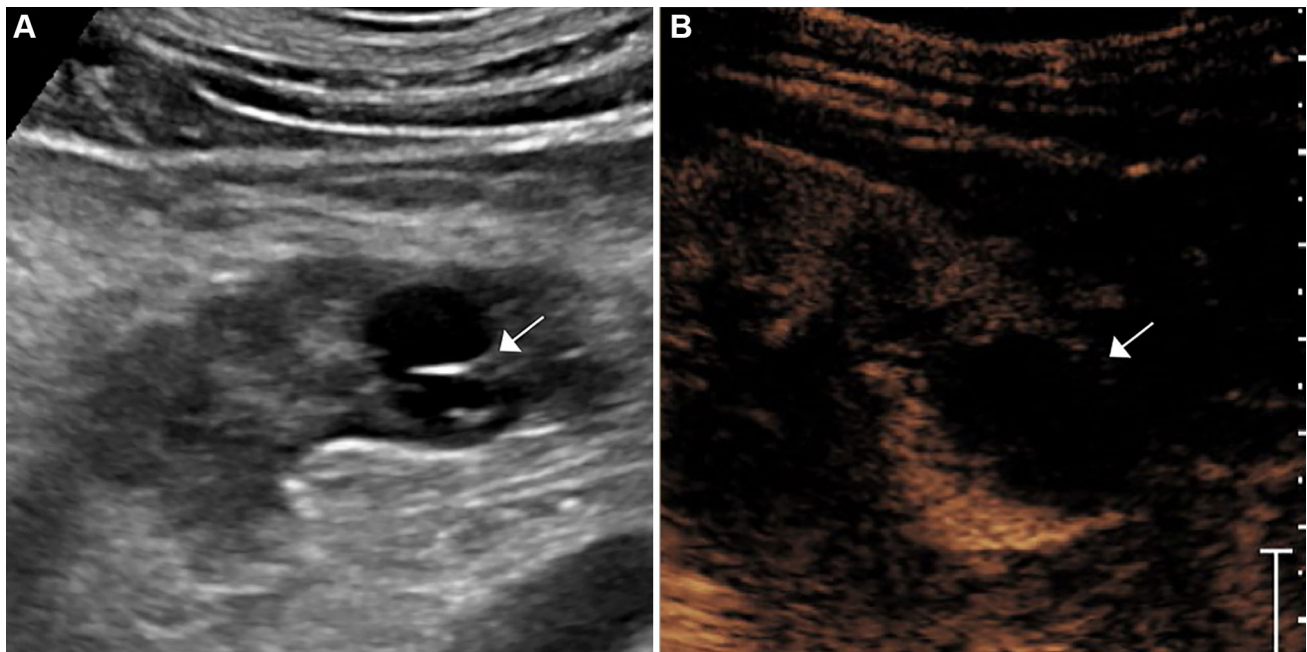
A 78-year-old man with a history of renal insufficiency and a complex left renal cyst. A Grayscale sonographic image of the left kidney demonstrates a cystic lesion at the left renal lower pole with internal septations (*arrow*).
